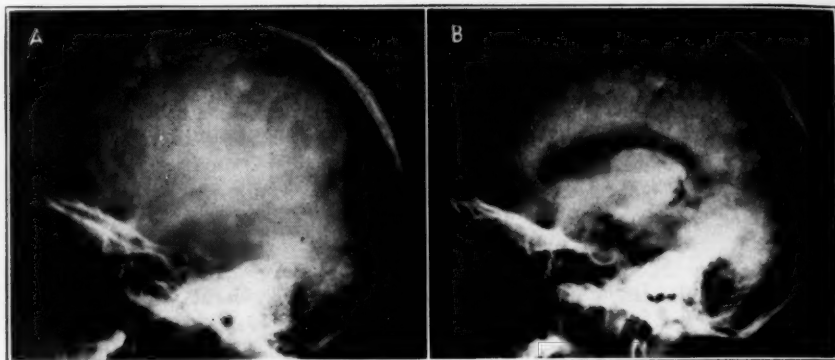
(case 7).—*A*, preoperative roentgenogram of the skull, showing the position of the calcified subcortical cicatrix, about 1.5 cm. beneath the surface of the brain and about 1.5 cm. from the midline. The patient, a 12 year old boy, had had convulsions since he was 1½ years old. *B*, preoperative pneumoencephalogram. Note how the roof of the lateral ventricle has been pulled upward by the calcified subcortical cicatrix. In addition to the convulsions, severe, progressive left hemiparesis was developing prior to operation.
